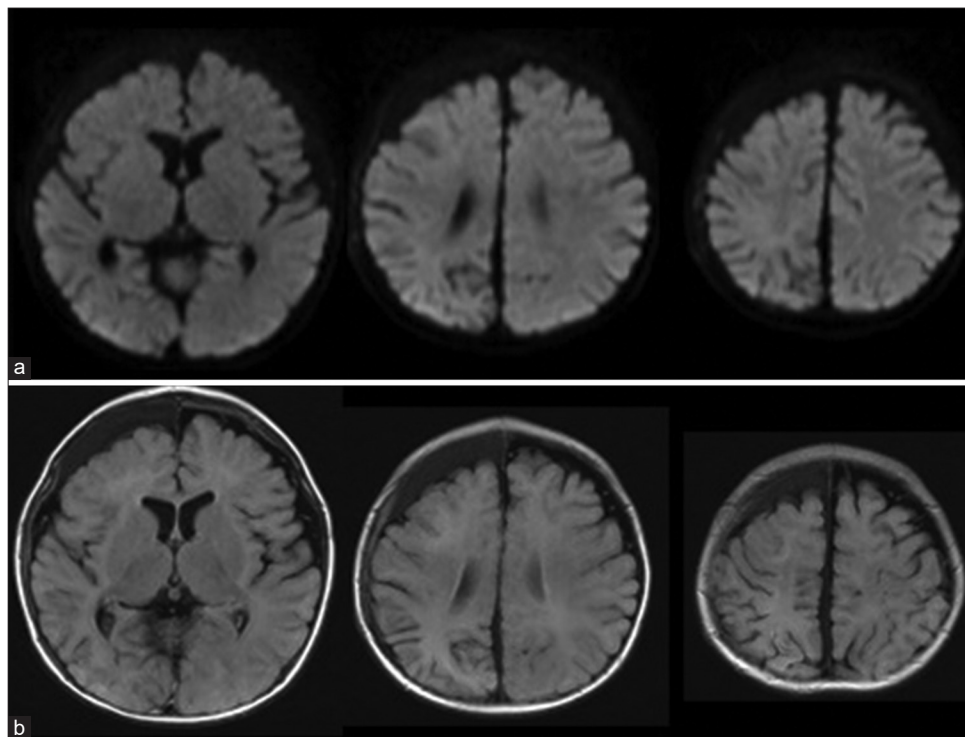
Magnetic resonance images on day 20 showed the abnormal signal intensity in the white matter of the right cerebral hemisphere completely disappeared on diffusion-weighted imaging (DWI), although the high-intensity area in the right parietal lobe with atrophy was observed on fluid-attenuated inversion recovery (FLAIR) images. (a) DWI. (b) FLAIR image.
